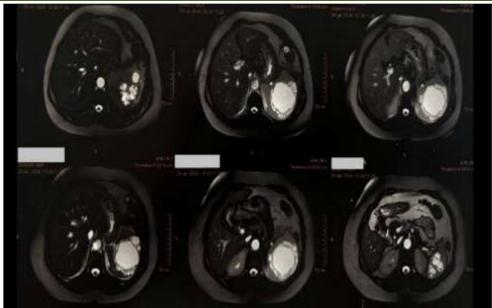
Abdominal MRI image showing T2 hyperintense cystic lesions in the spleen
